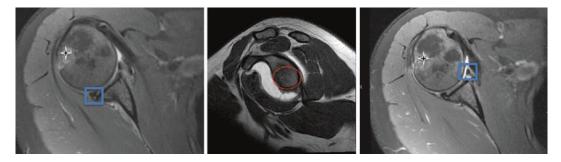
Diagnostic MRI showing anterior and posterior labral lesions in blue box on axial sections; sagittal projection is confirming no significant glenoid bone loss
